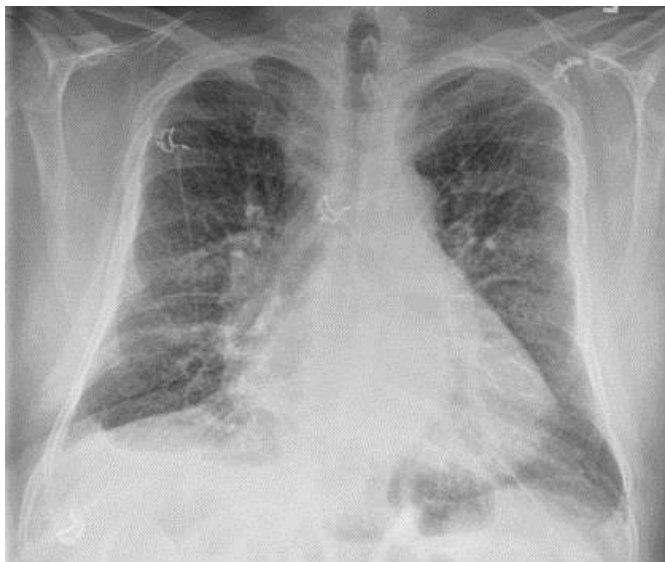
Admission chest x-ray.
